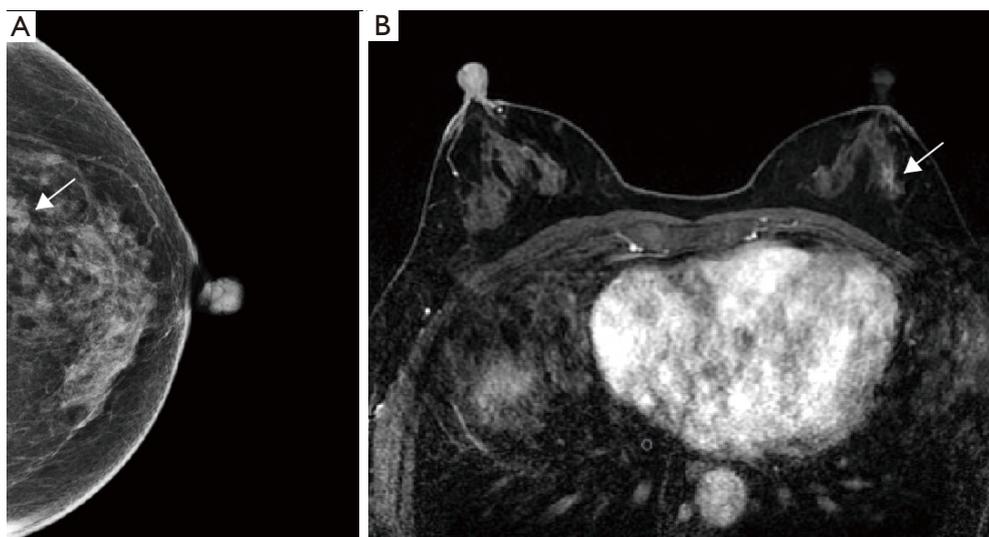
Female, 58 years old, with negative ultrasound finding. The mammography craniocaudal image (A) showed local architectural distortion in the deep lateral part of the left breast, BI-RADS 0. The MRI obtained in the post-contrast phase (B) showed a small, patchy enhanced area at three points in the left breast with local architectural distortion, which was consistent with the mammography, BI-RADS 4A. The pathology was confirmed to be sclerosing adenosis with low-grade DCIS. BI-RADS, Breast Imaging Reporting and Data System; MRI, magnetic resonance imaging; DCIS, ductal carcinoma in situ.
